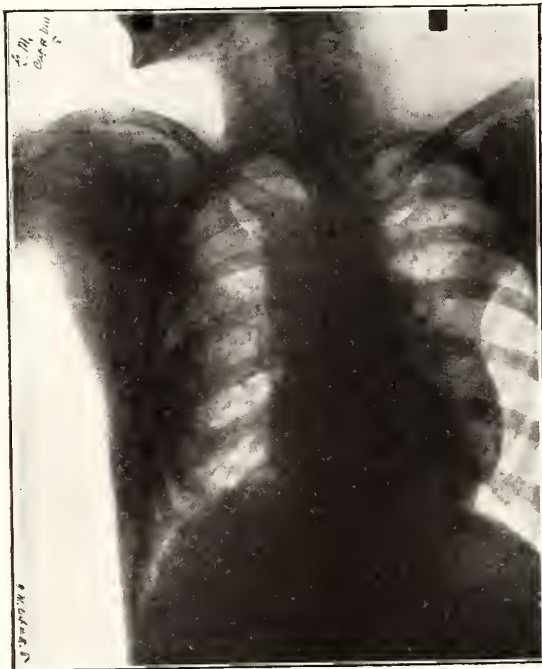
Radiograph of aneurism described in report of case No. 6.
